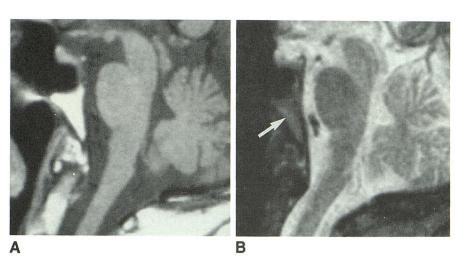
Normal clivus on T1- and T2-weighted midline sagittal images in a 63-year-old woman.
